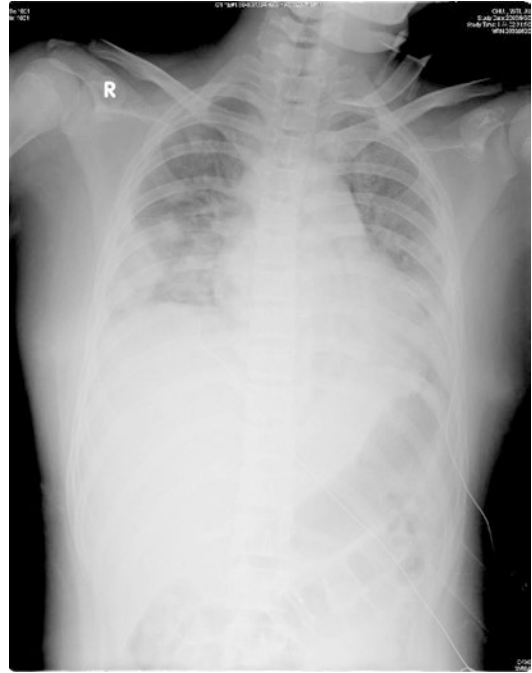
A chest radiography on Hospital day 2 showed probably septic emboli and right side pleural effusion/empyema
